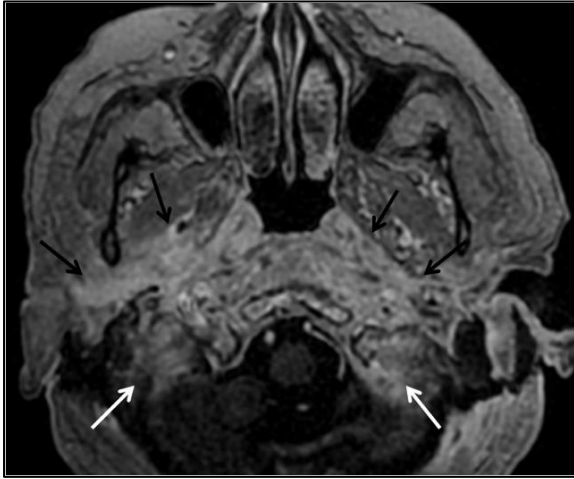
Contrast-enhanced axial T1-weighted image shows diffuse contrast enhancement in bilateral parapharyngeal, pharyngeal mucosal, retropharyngeal and carotid spaces, partially parotid space on the right, and jugular fossa on both sides (arrows).
